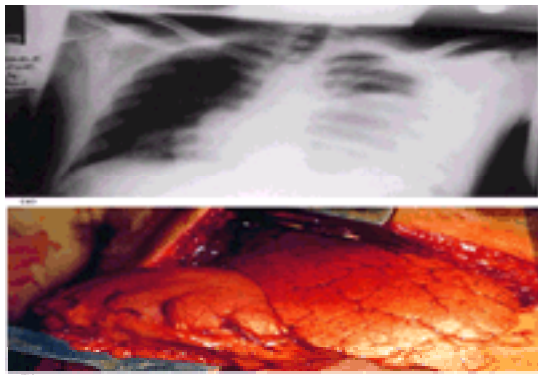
Ruptured left hemidiaphragm after blunt chest trauma. (a) Plain radiograph. (b) Stomach in chest at thoracotomy.
